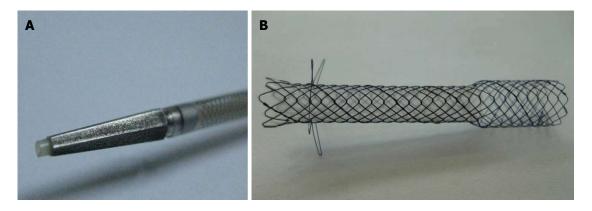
Gross finding of dedicated device for one-step endoscopic ultrasound-guided biliary drainage system. A: The 7F delivery sheath and 3F catheter with 4F tapered pentagonal metal tip; B: Gross finding of the metallic stent. The uncovered proximal end of the stent (8 mm in diameter and 15 mm in length), the body and distal portions of the covered stent with a silicone membrane (6 mm in diameter and 35 or 45 mm in length), and the distal end with four flaps.
